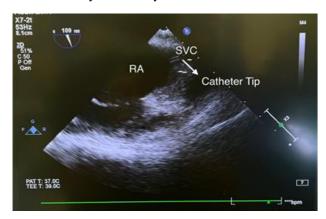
Transesophageal echo showing catheter tip
